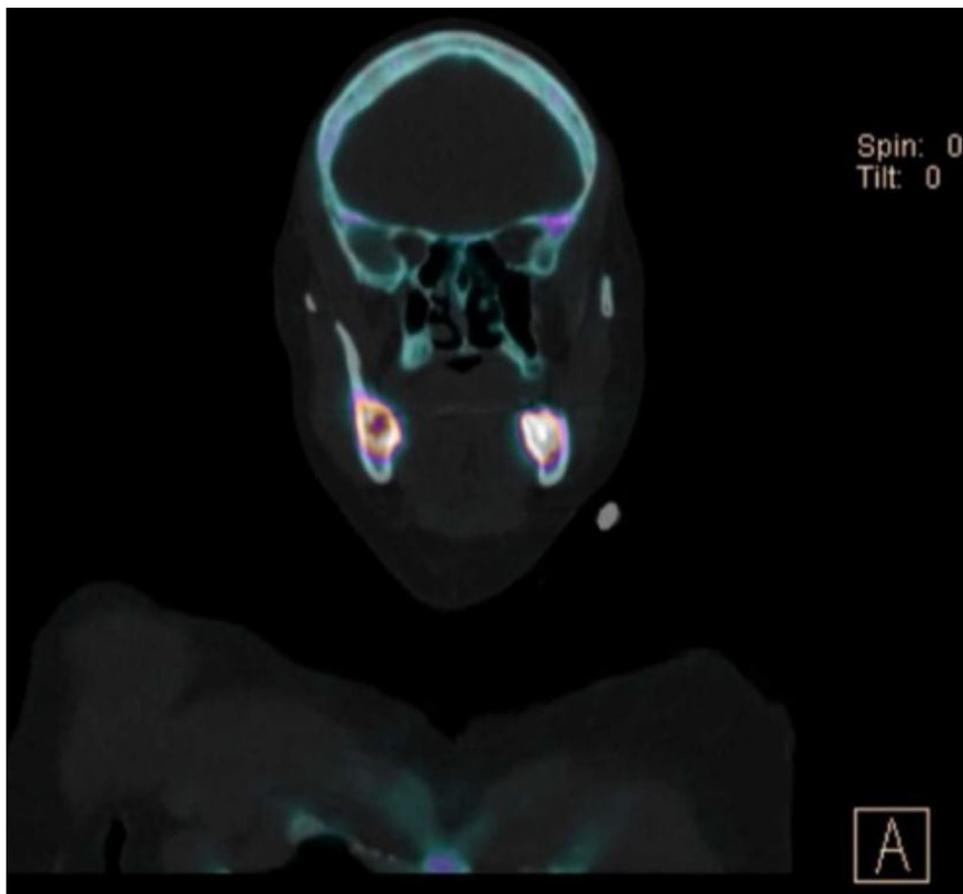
Bone scintigraphy showing radio-uptake that is suggestive of osteonecrosis or bilateral osteomyelitis.
